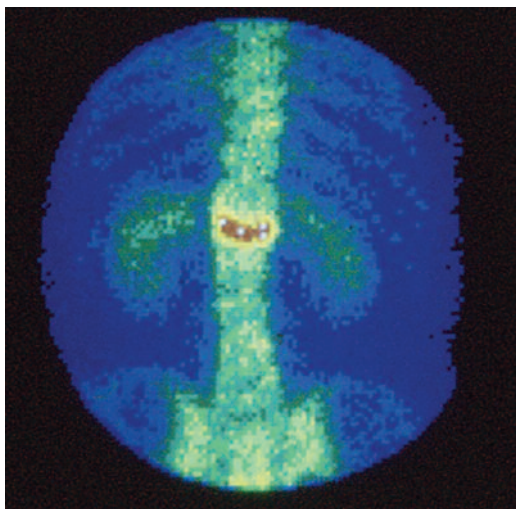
Bone scintigraphy with Technetium-99m-diphosphonates planar image (*posterior view*) in a 44 year-old female patient with spondylodiscitis showing increased tracer uptake between D12 and L1.
